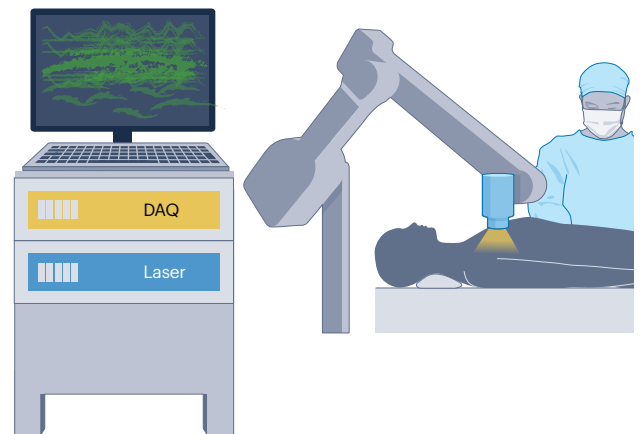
Various clinical PAI system configurations. a, Dual-modal photoacoustic and ultrasound imaging (PAUSI), based on conventional ultrasound imaging (USI) systems, can be categorized into a handheld type with linear-array ultrasound transducers (USTRs) and an endoscopic-type with endocavity array USTRs. Primary diagnostic sites for the handheld-type system include the skin, thyroid, breast and limbs; diagnostic sites for the endoscopic-type system
